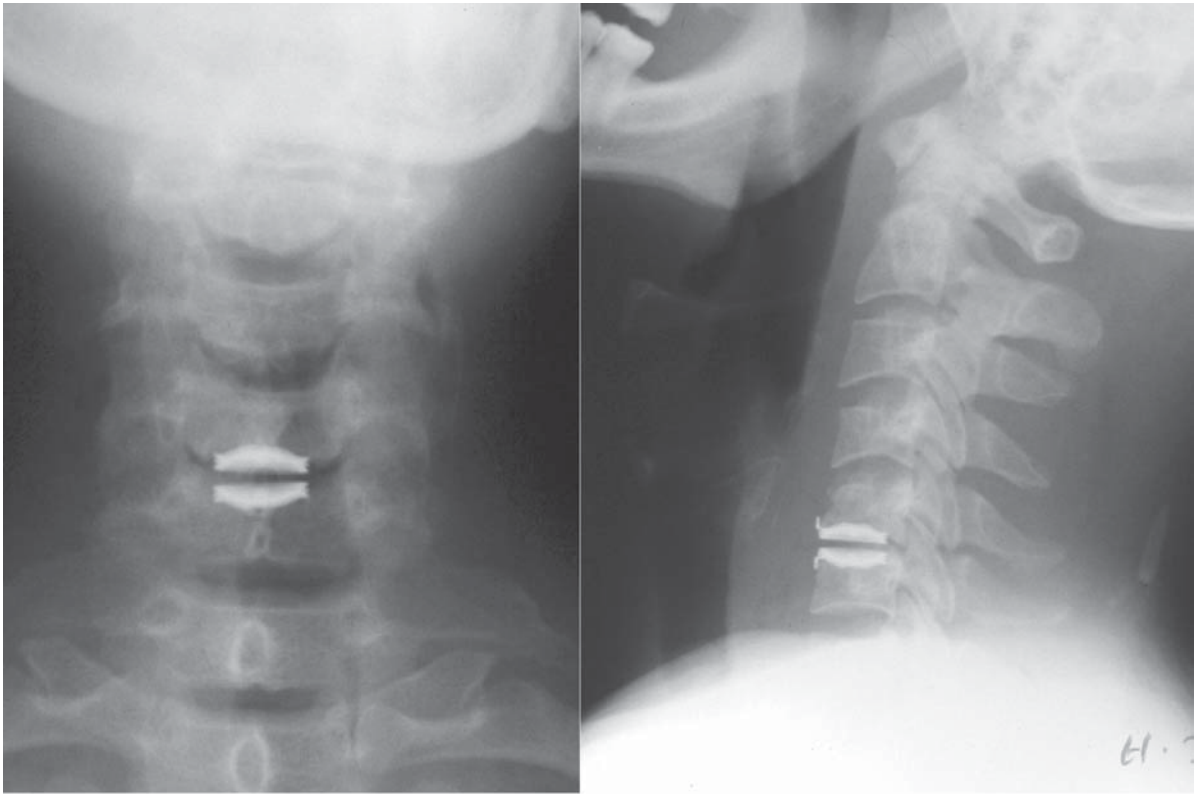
X-rays showing single level Bryan disc prosthesis at C5-C6 level.
